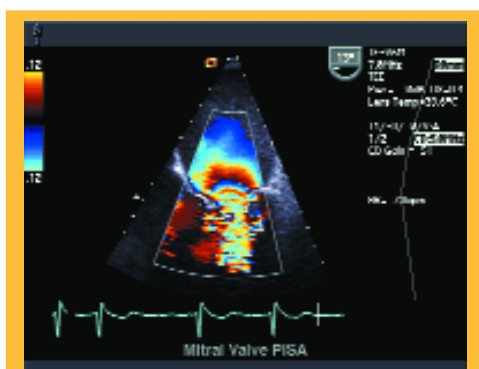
Severe mitral regurgitation in MVP seen from transoesophageal view. The colour Doppler in the proximal LA is seen to consist of hemispherical isovelocity shells. The radius and velocity of these shells can be used to calculate regurgitant volume (see text).
